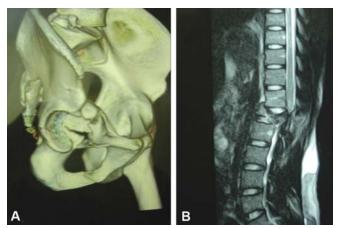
CT scan showing acetabular fractures and MRI of the spine showing compressed fracture of the vertebra
